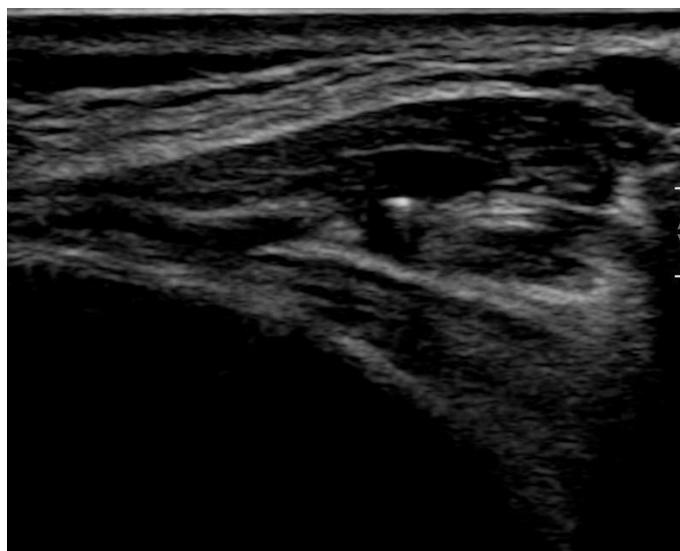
Doppler ultrasonography performed 2 months postoperatively showing that the blood flow in the mastoid emissary vein had stopped.
